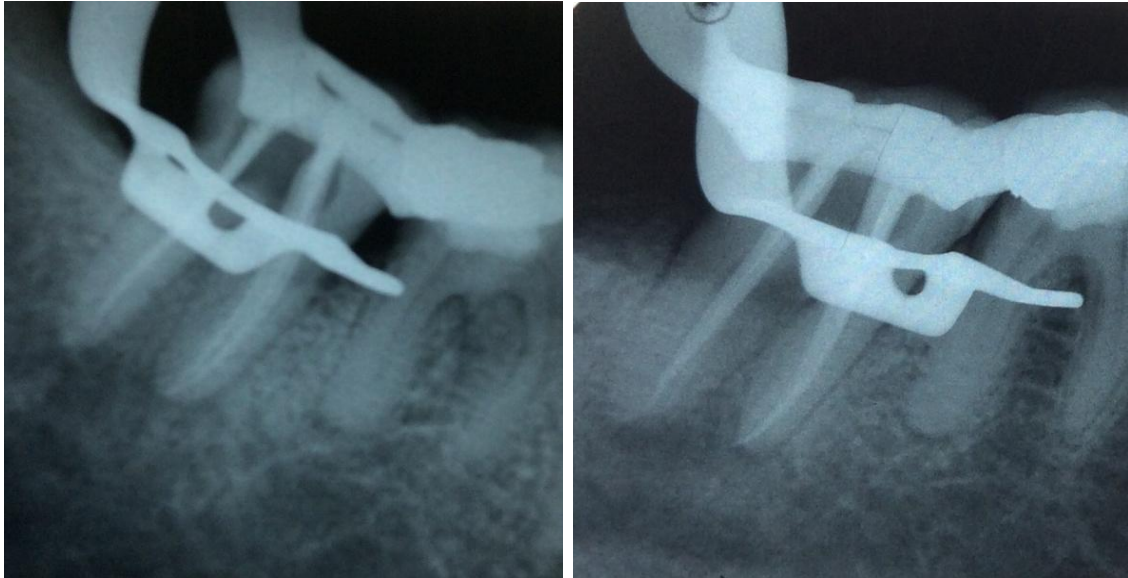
Master cone in angled radiograph
